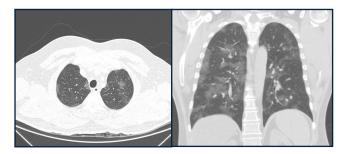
Admitional chest computed tomography in axial and coronal view with interstitial pneumonia.
